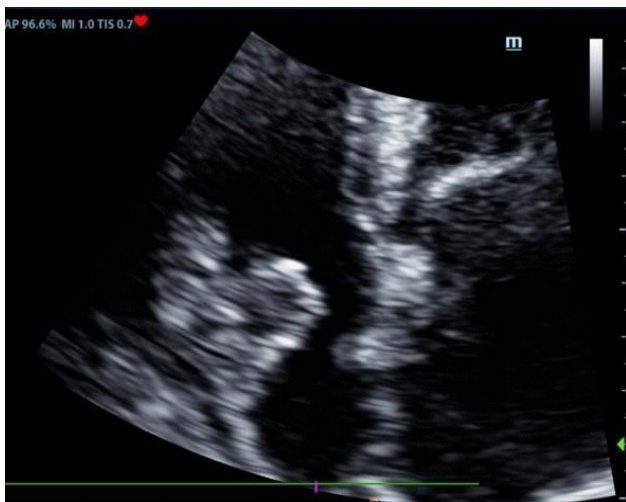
Transthoracic Doppler echocardiogram, apical window, right atrium-focused view, showing a vegetation on the right atrial free wall.
